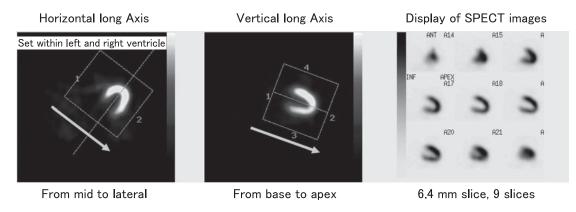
How to reformat and display myocardial SPECT
